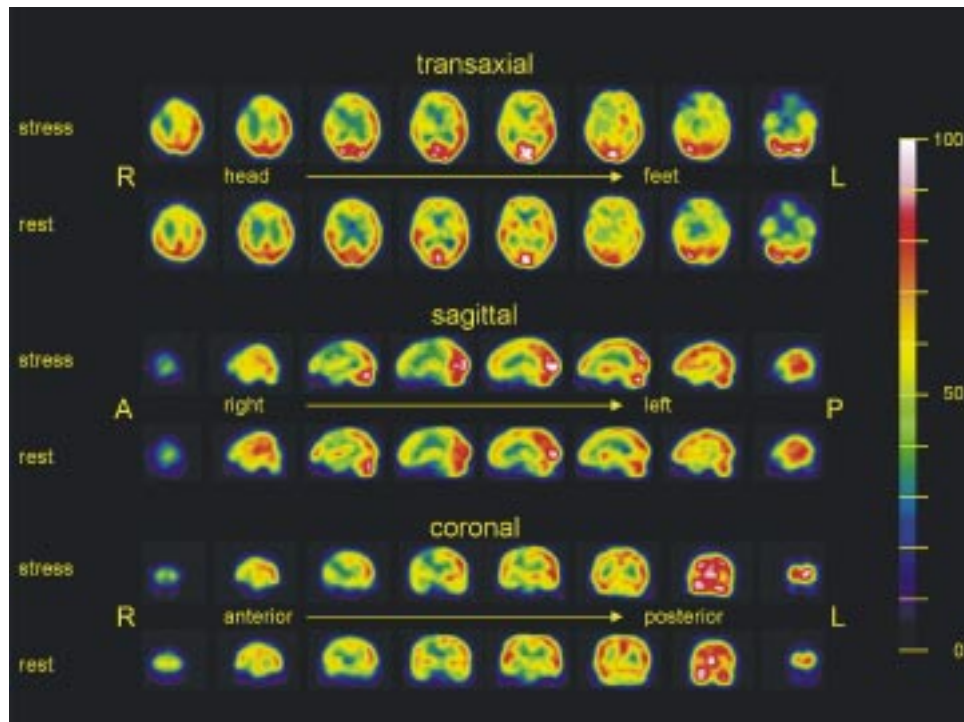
58-year-old female patient with acute complete occlusion of the right internal cerebral artery, accompanied by hemiparesis on the left side. A 70%-stenosis of the left internal cerebral artery was known in the patient's history. SPECT images were obtained under rest and under pharmacological stress (using a carbonic anhydrase inhibitor) after application of 250 and 750 MBq ^{99m}Tc -ECD, respectively. The stress study revealed a larger perfusion deficit in the right fronto-parietal cortex when compared with the rest study, thereby indicating an impaired perfusion reserve. Additionally, a crossed cerebellar diaschisis was found.
